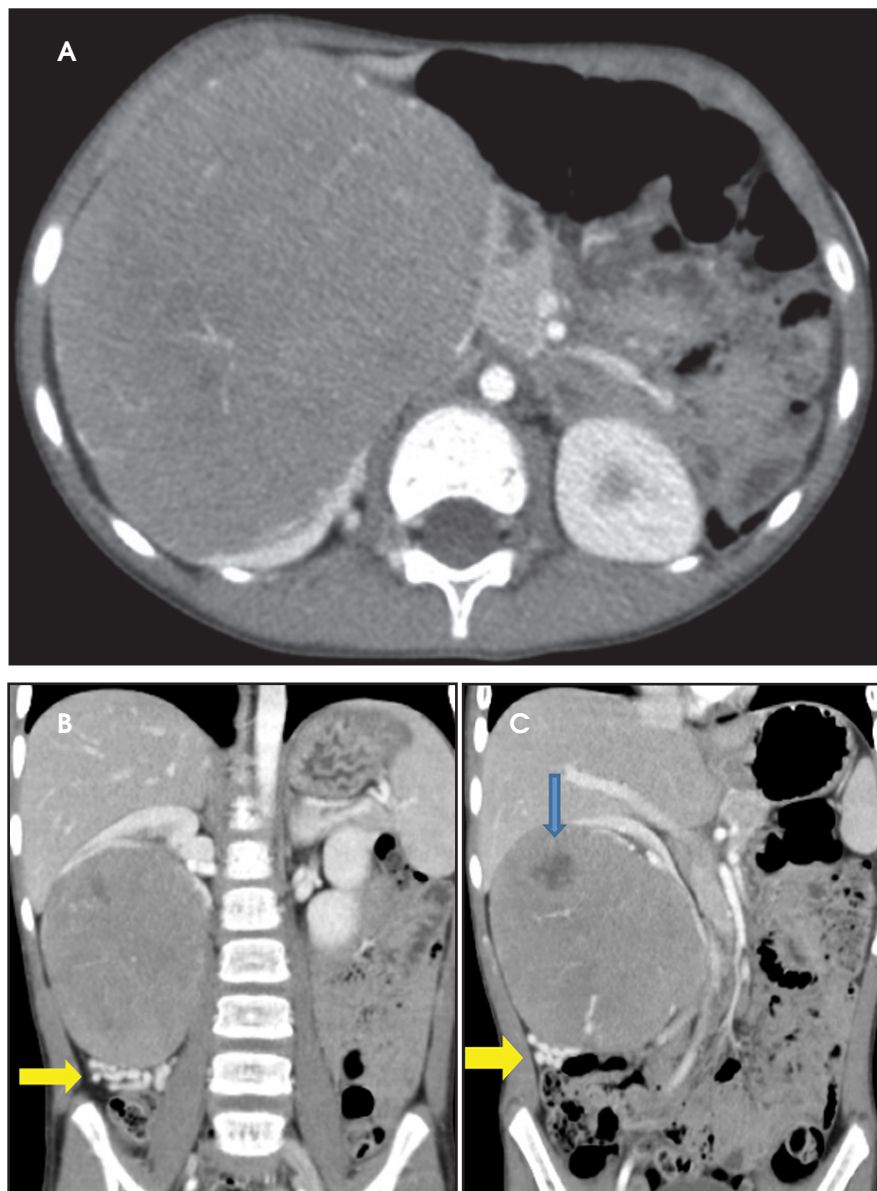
(A) Contrast-enhanced axial CT shows a large enhancing soft tissue mass arising from the mid and lower pole of the right kidney, and normal renal cortical rim posteriorly. (B) Contrast-enhanced coronal CT demonstrates a large heterogeneously enhancing mass arising from the lower pole of the right kidney with tortuous veins inferior to the mass (arrow). (C) Contrast-enhanced coronal CT demonstrates hemorrhage, cystic degeneration, or necrosis (blue arrow) within the large heterogeneously enhancing mass arising from the lower pole of the right kidney and tortuous veins inferior to the mass (yellow arrow).
